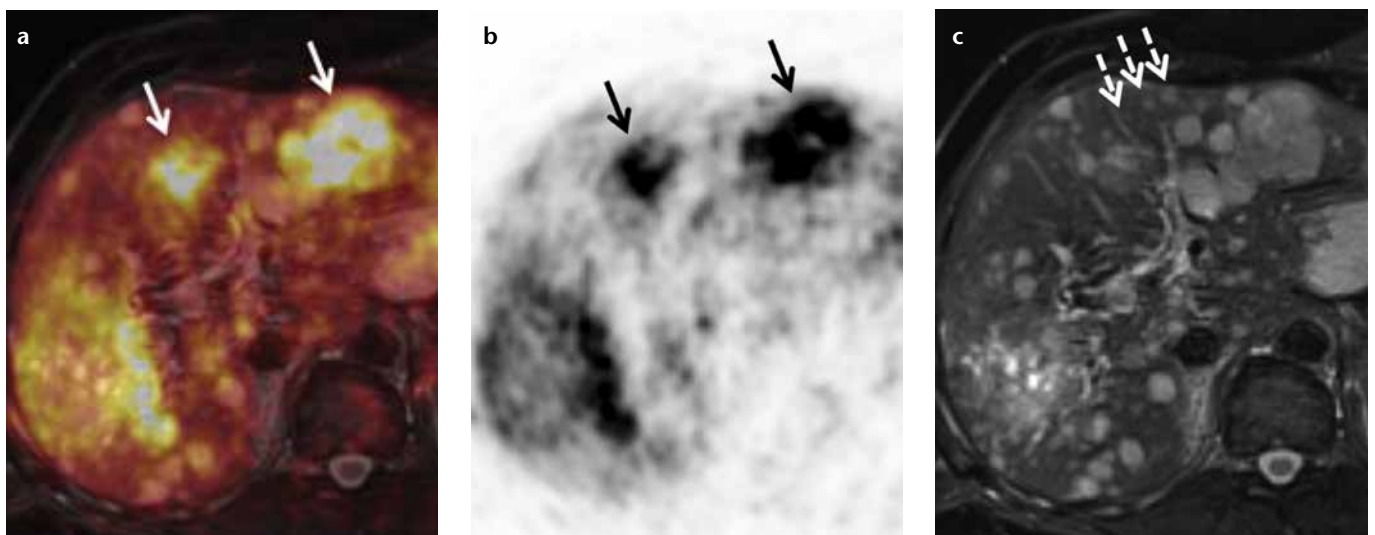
a–c. Simultaneous PET/MRI with ^{68}Ga -DOTATOC in a patient with liver metastases originating from a neuroendocrine tumor (NET) of the pancreas. While PET is very specific and identifies liver metastases due to a NET-specific somatostatin-receptor overexpression (a, fusion; b, PET; arrows), its spatial resolution especially in an organ prone to respiratory motion is limited. T2-weighted MRI allows for correct identification of liver metastases <1 cm in size (c, dashed arrows). Since CT is less sensitive and less specific than MRI in liver metastases <1 cm in size, the combination of PET and MRI for the assessment of liver metastases appears to be a very powerful combination.
